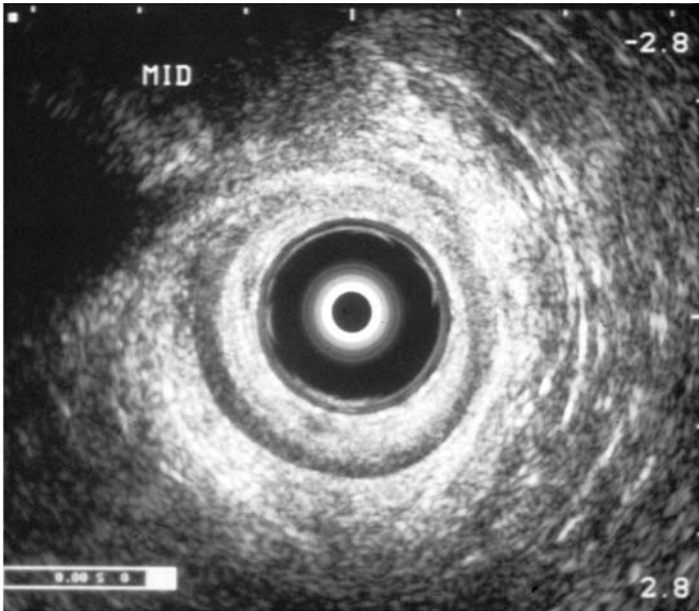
Endo-anal ultrasound demonstration of combined internal and external sphincter defect.
